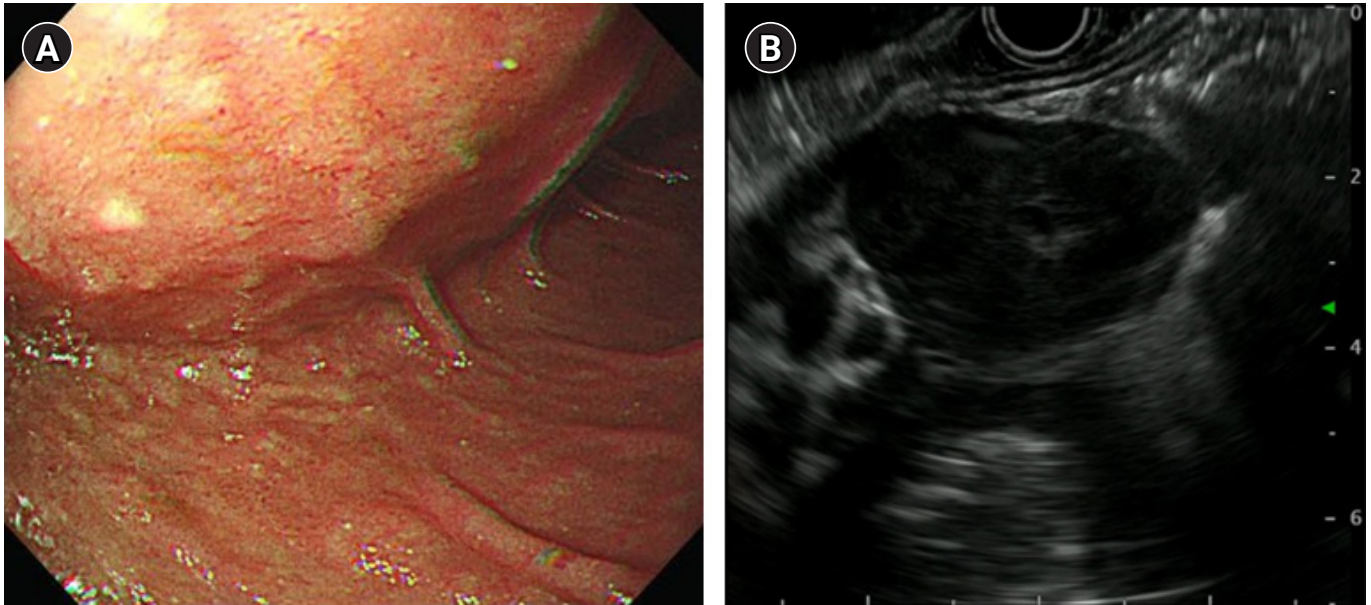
Endoscopic and endoscopic ultrasonographic findings of gastrointestinal stromal tumor. (A) Bulging at the duodenal second portion and (B) an inhomogeneous hypoechoic oval mass with regular margins and a largest diameter of 42 mm.
